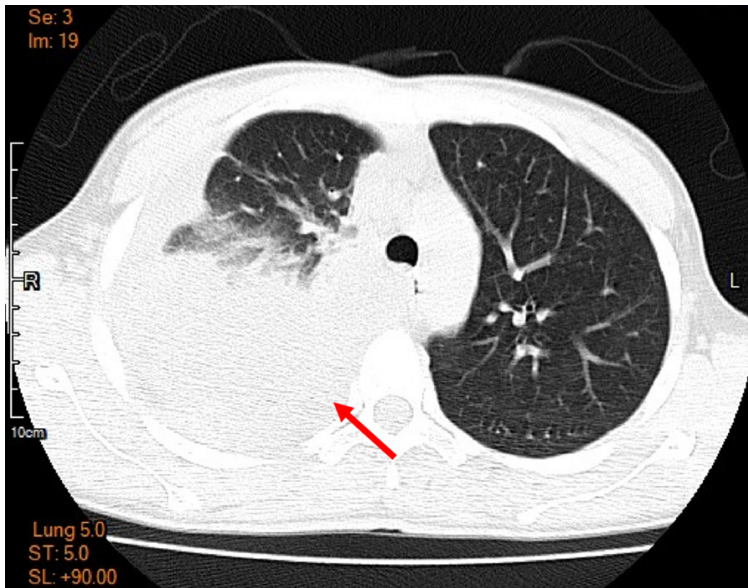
Chest CT (lung window setting) showed a huge 16 × 14 cm tumor mass in the right lung (arrow).
